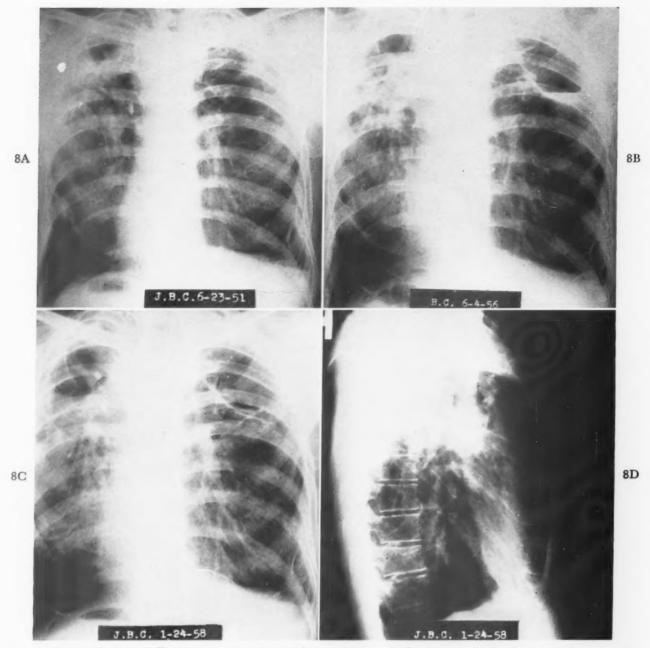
Case iv. A through D, chest roentgenograms taken approximately five years apart showing marked progression bilateral infiltration and enlargement of the cavities. Left hilar calcification is present. Chest roentgenograms taken January 24, 1958, show greater extension of the pulmonary histoplasmosis and large cavity formation.
